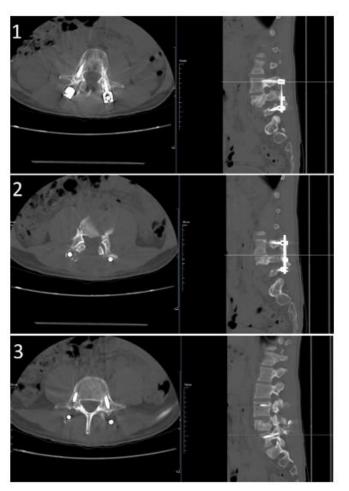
Post operative CT Scan (axial and sagittal view respectively) showing regained vertebral body height. Image 1 and 3showing posterior fixation of L3 and L5 respectively and Image2 showing laminectomy of L4.
